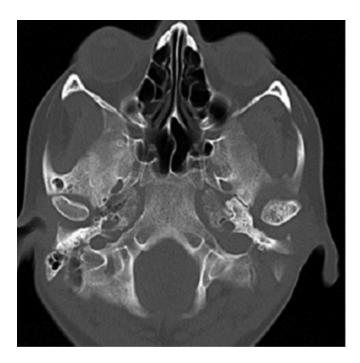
Axial CT exhibiting hyperplastic left condyle.
